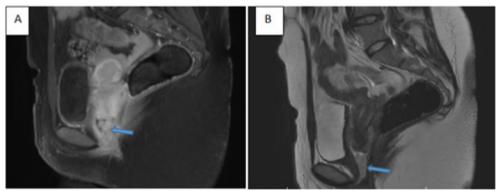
Magnetic resonance imaging showing a mass infiltrating the vaginal wall on sagittal T2-weighted images (A) and strongly enhanced after injection of gadolinium on sagittal T1-weighted images (B).
